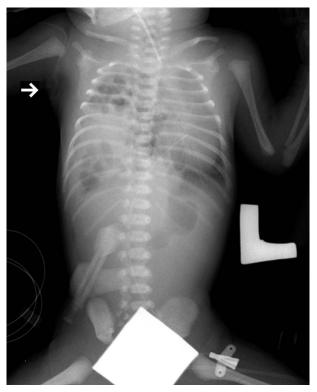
Chest X-ray of a newborn on the first day of life: displacement of the intestines to the right part of the chest and a shift of the heart to the left
